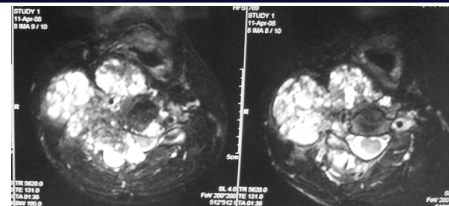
B) CT&MR images of C 5 vertebra show GCT with secondary ABC
